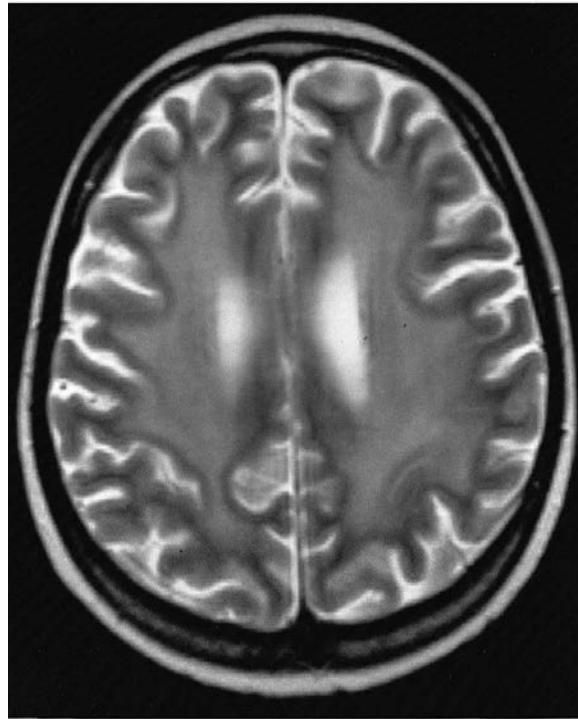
Axial T2W MRI brain showing radiation leukoencephalopathy and generalized cortical atrophy. 19-year-old girl with Philadelphia positive ALL post bone marrow transplant (matched unrelated donor) who had received whole brain RT as part of the conditioning protocol and subsequently methotrexate. She presented with a 3-month history of personality change, withdrawal, perseveration, incontinence and abulia, and the MRI scan showed confluent high signal change throughout subcortical white matter. She died 2 weeks later.
